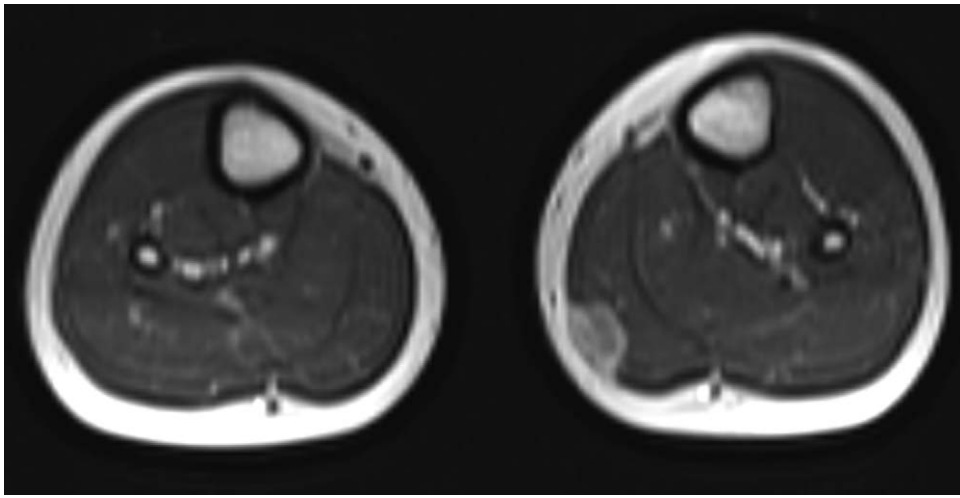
MRI showing a subfascial well-circumscribed lesion with intramuscular extension in the medial gastrocnemius muscle of the left leg. MRI = magnetic resonance imaging.
